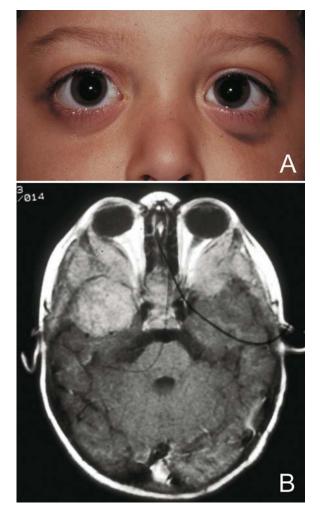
(A) Bilateral ecchymosis of the eyelids and periorbital skin of a patient with metastatic abdominal neuroblastoma of both orbits and brain. (B) Multiple metastatic nodules in orbits and brain are shown in T-1 weighted axial MRI image. (Courtesy of Dr. Robert A. Gordon of New Orleans, Louisiana.)
